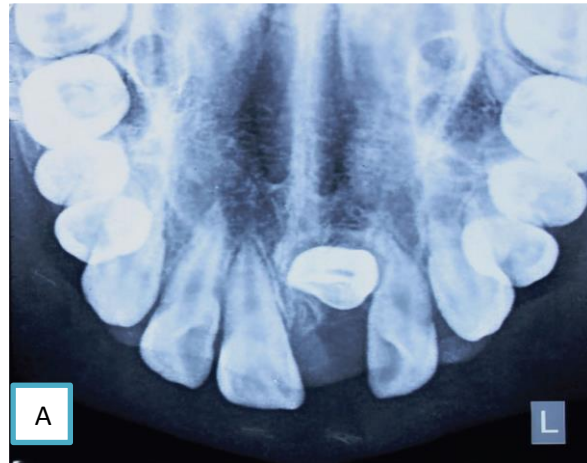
Occlusal radiographic image of a child with maxillary left permanent central incisor dilaceration. (Topouzelis *et al.*, 2010)
